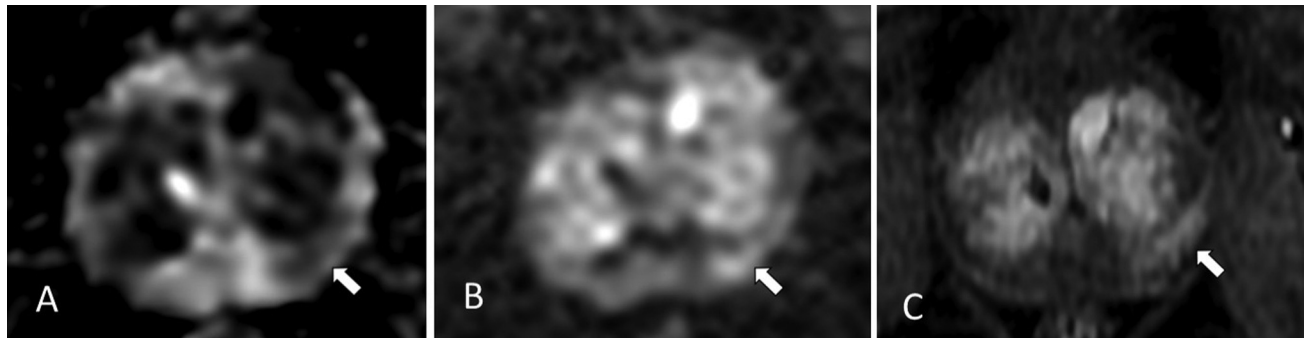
Prostate Imaging Reporting and Data System (PI-RADS) score 3 lesion (A, B – apparent diffusion coefficient [ADC]/diffusion-weighted imaging [DWI] axial sections) with early enhancement (C – dynamic contrast-enhanced [DCE] T1 axial sections), can be upgraded to PI-RADS 4 final category.
